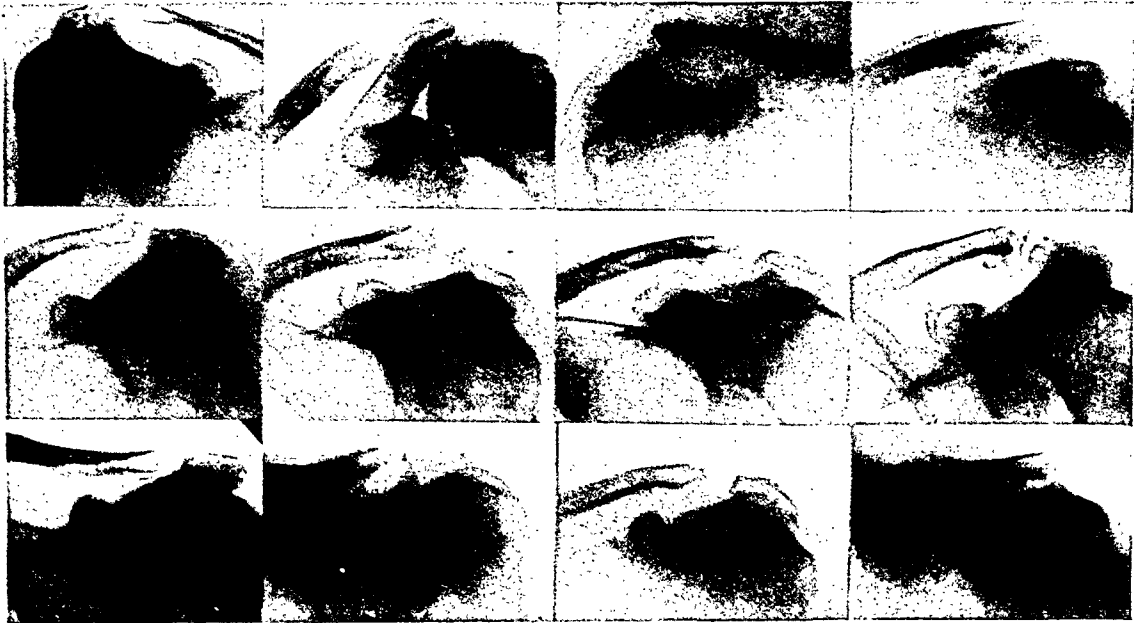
After-effects of tearing of the coracoclavicular ligaments associated with acromioclavicular dislocation without any medical attention. The cases are arranged according to length of time from the injury to the x-ray examination. The first column on the left (three cases) within one month after injury: second within three months: third within nine months: and fourth over one year after injury. All these patients had some difficulty in lifting weights, or on prolonged pushing of hand truck or in pulling a rope.
